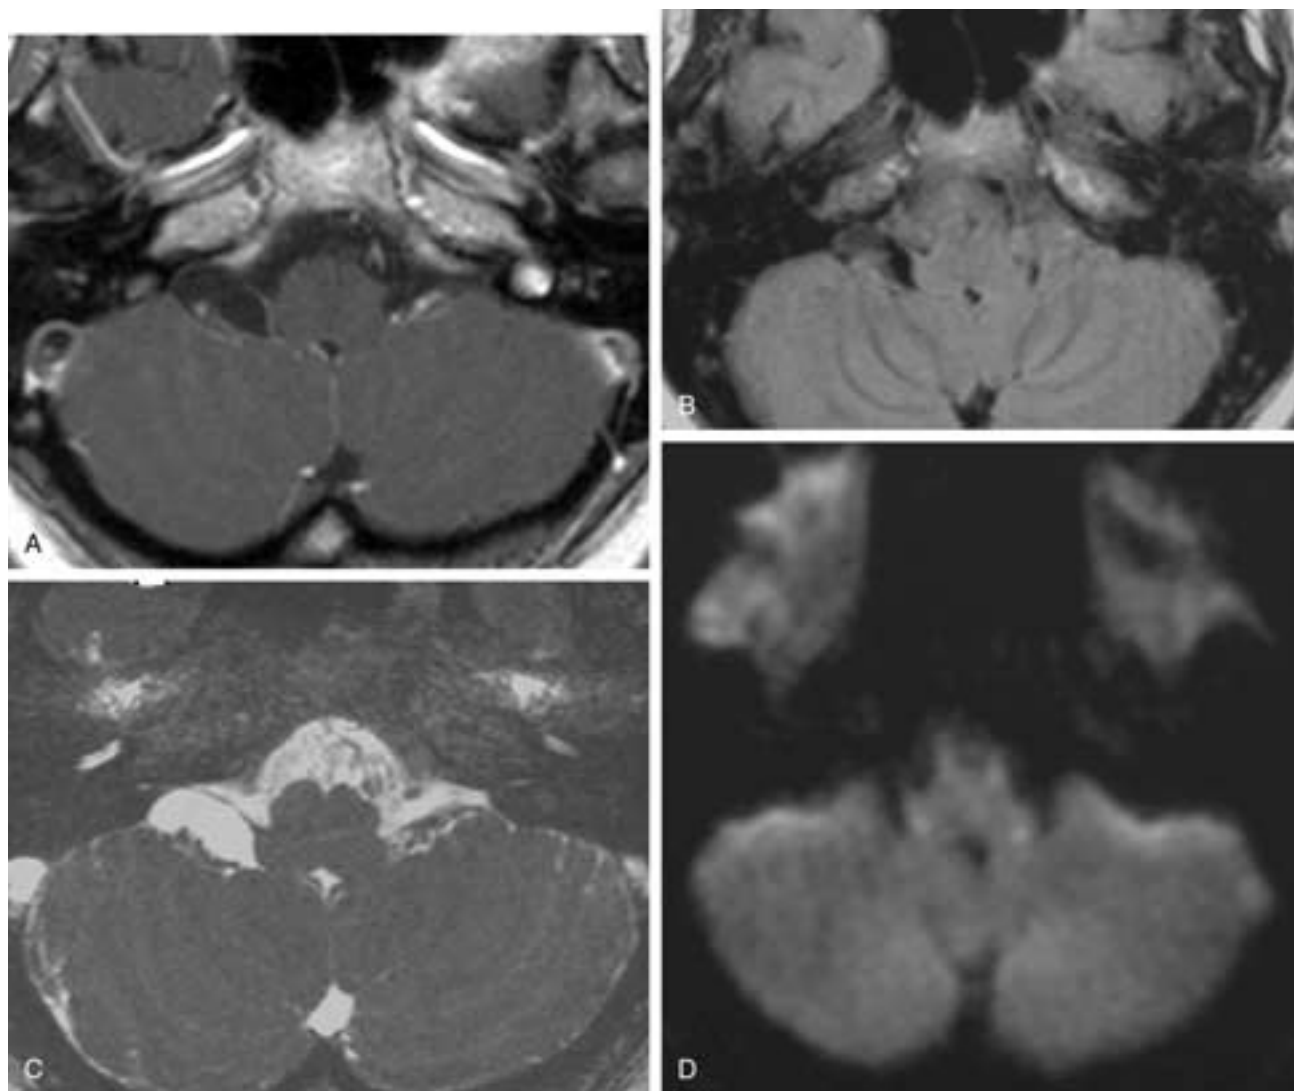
CPA arachnoid cyst. A, T1-weighted postgadolinium image. B, Proton density image and C, T2-weighted image. There is a cyst in the right CPA with a moderate mass effect on cranial nerve IX and the cerebellum. The nonenhancing cyst has a smooth surface, its signal tracking with CSF. D, Diffusion-weighted image. The low signal intensity of the cyst, similar to that of CSF, confirms the pure fluid contents, differentiating it from epidermoid.
